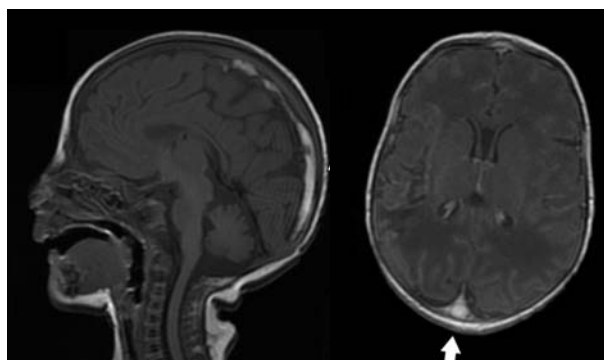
Magnetic resonance imaging of the head showing occlusion of the superior sagittal sinus.
